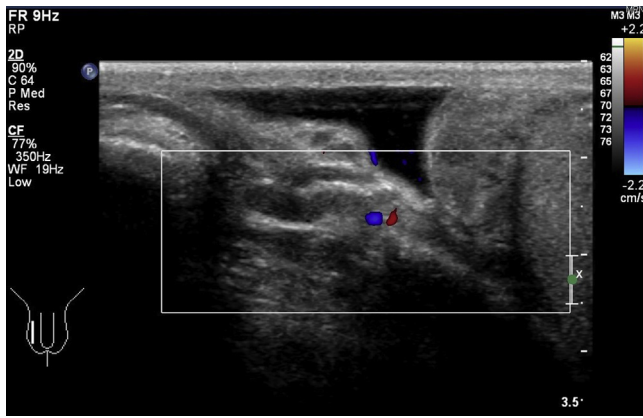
The USG image of our patient demonstrated a twisted cord, reduced echogenicity of right testis and diffusely enlarged epididymis with near absent color doppler flow.
